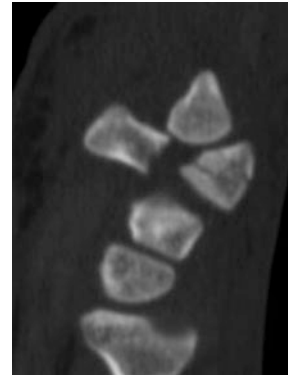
Sagittal CT demonstrating a fracture of the hook of the hamate. This was not visible on conventional radiographs
